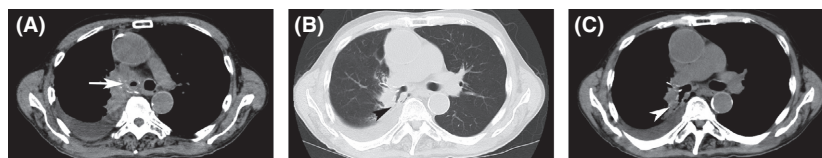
Chest CT scan showing (A) a right main bronchial stricture (arrow) near the tumor, which increased with right pleural effusion. (B, C) A cavity connected to the right main bronchus via a tube-like hollow space (arrowhead) in the tumor. (B) and (C) are the same images with different CT window settings. (B) CT lung window settings. (C) CT mediastinal window settings.
